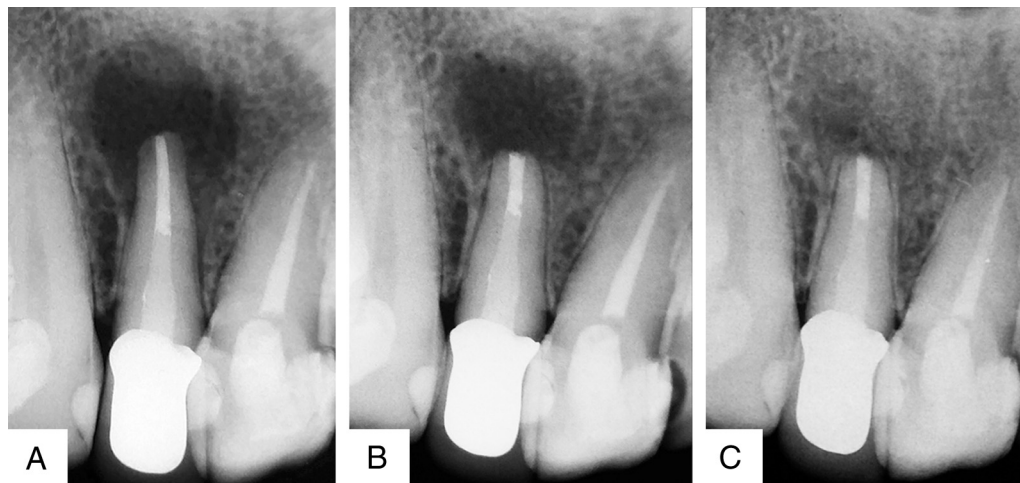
A tooth treated with photodynamic therapy during surgery. (A) The preoperative radiograph, (B) the postsurgical radiograph, and (C) the follow-up radiograph (13 months).
